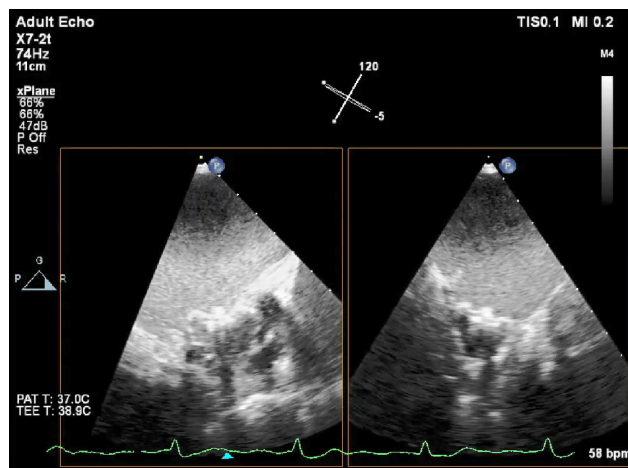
Transoesophageal echocardiography in a patient with a Watchman left atrial appendage (LAA) closure device. Microbubble-enhanced ultrasound was used in order to detect a suspected residual leak around the occluder. On non-enhanced multiplane and live 3D images (A) a gap is visible (red arrows) between the rim of the device and the LAA. Because of shadowing, the sealing of the LAA cannot be verified. By adding intravenous contrast (B) and using harmonic imaging with a mechanical index of 0.2, contrast is seen in the LAA, surrounding the device (yellow arrows), demonstrating incomplete sealing of the LAA. Source: personal collection.
